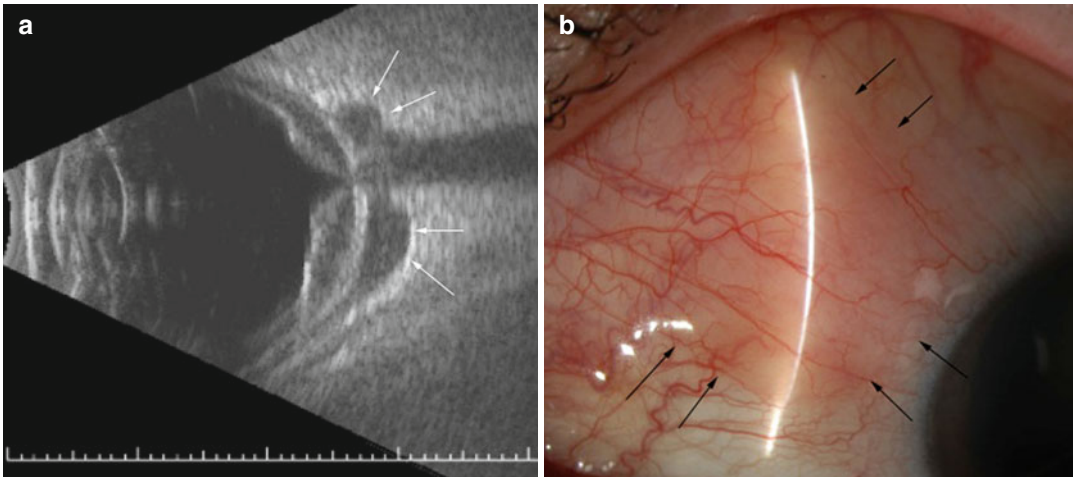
B-scan ultrasonography reveals peripapillary nodules (*arrows*) suspicious for lymphoma (a). Anterior segment examination of the same patient
